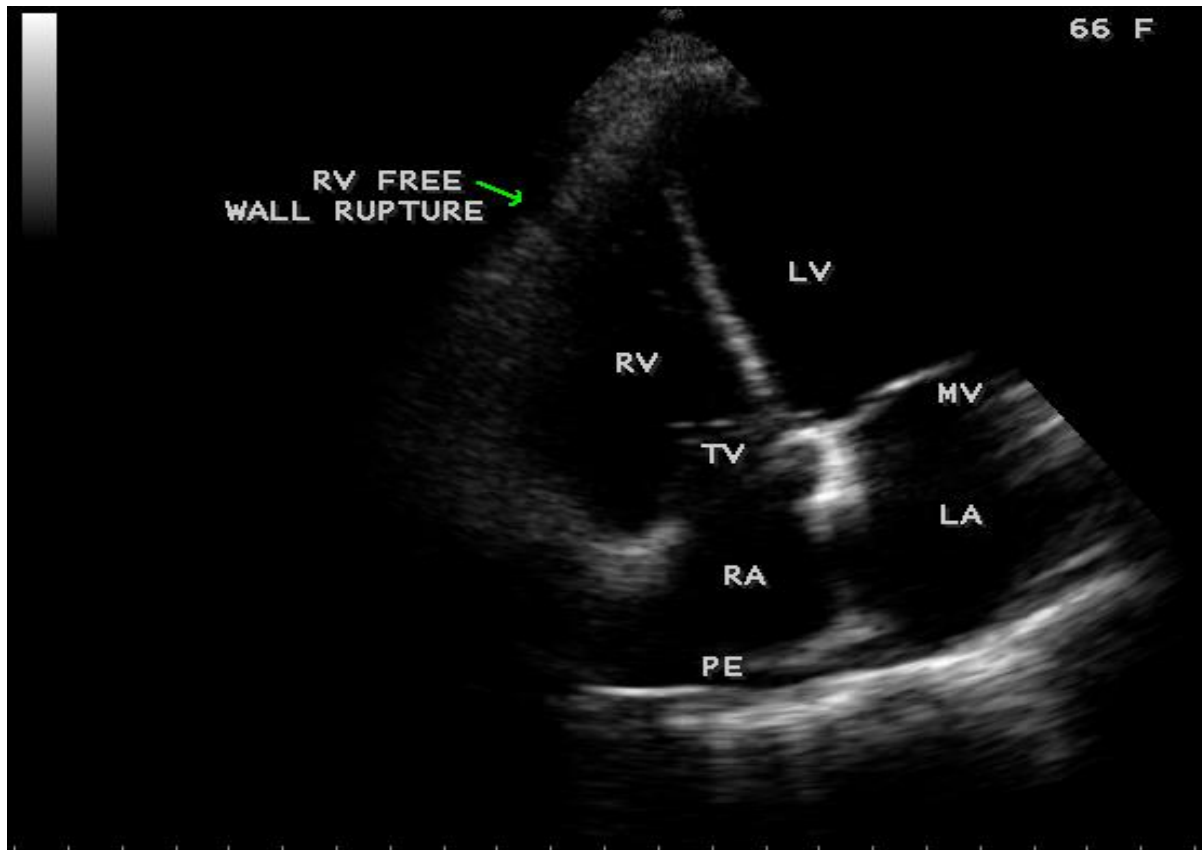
2D echocardiographic imaging showing the small RV (right ventricular) free wall rupture in a 66-year old female with acute inferior wall infarction in apical four chamber view.
